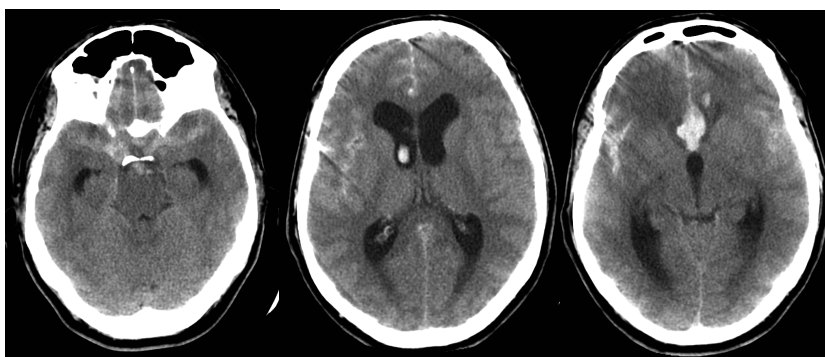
CT scan of SAH with an intraventricular and intracerebral hematoma.
